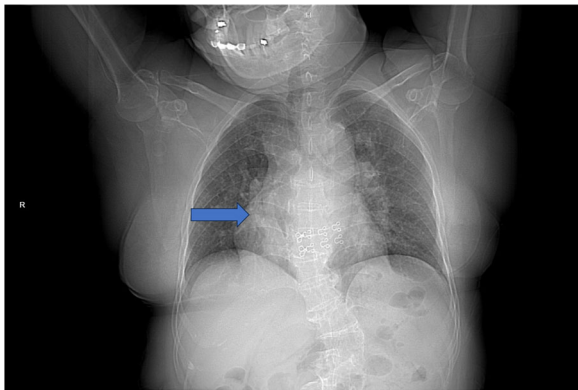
Chest X-ray findings: A smooth curving structure projecting across the right pulmonary hilum toward the base of the lung.
